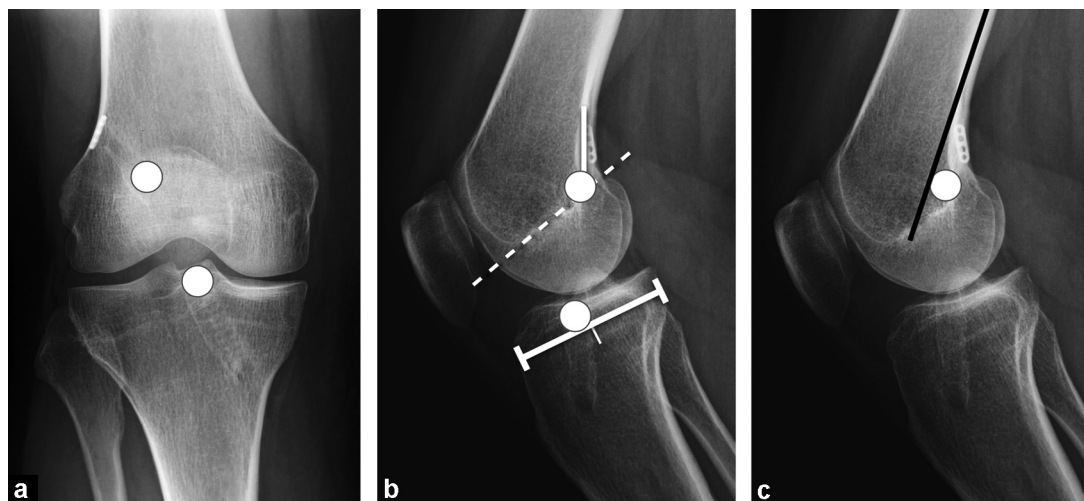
Normal placement of tunnels on standard radiographs. White rounds indicate the apertures of the tunnels: a: on frontal view, the femoral tunnel aperture should be located in the superolateral part of the intercondylar notch, and the tibial tunnel aperture projecting from the medial tibial spine; b: sagittal view: the femoral tunnel aperture should be at the junction of the line drawn along the posterior femoral cortex and the line drawn along the roof of the intercondylar notch, also called Blumensaat line (white dotted line). The posterior border of the tibial tunnel aperture must correspond to the middle of the tibial epiphysis. The graft, the location of which can be inferred from the location of the two apertures, must be located behind the Blumensaat line to avoid anterior impingement. Maximum extension is better to assess the graft; c: another useful marker is the femoral tunnel aperture located behind the line extending from the posterior femoral cortex (black line).
